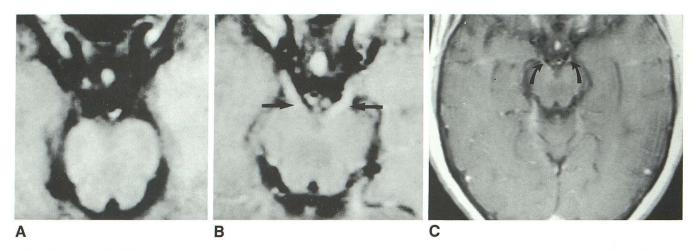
Patient 2; 67-year-old woman with chronic lymphocytic leukemia; no third cranial nerve palsy. Axial pre- (A) and postgadolinium (B) T1-weighted (600/20) images demonstrate bilateral enhancement of the third nerves (*arrows*). Axial T1-weighted image (C) postintrathecal chemotherapy shows decreased but persistent enhancement (*curved arrows*).
